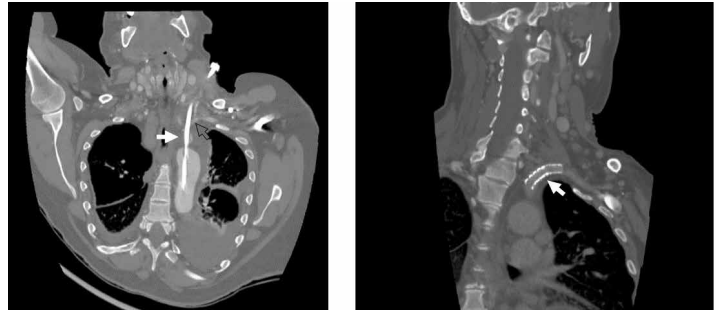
Right picture shows a computed tomographic reconstruction with misplaced dialysis catheter (white arrow) in left subclavian artery (grey arrow). Left picture shows a computed tomographic reconstruction after endoscopic placement of Advanta 10x38 mm stentgraft (white arrow) in left subclavian artery
